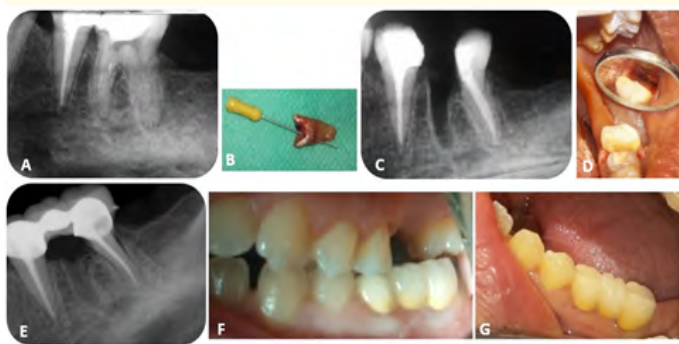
Instrument fractures are seen in the mesiobuccal and mesiolingual roots of tooth number 36 that had previously undergone root canal treatment. The mesial root of the teeth, which had increased periodontal gap, periapical radiolucency of mesial and distal roots, is narrow and curved at the points where the broken files are located.
